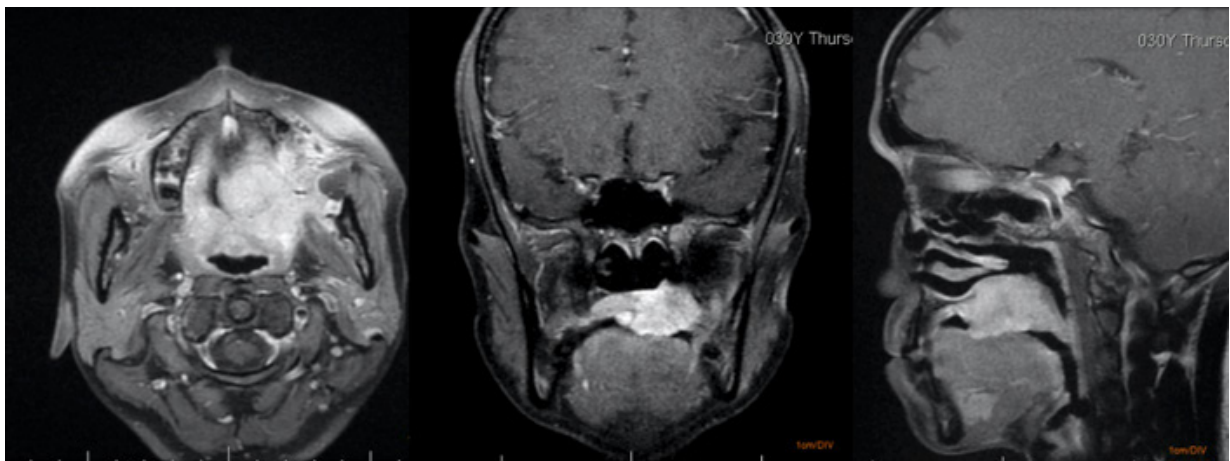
Facial MRI with contrast.
